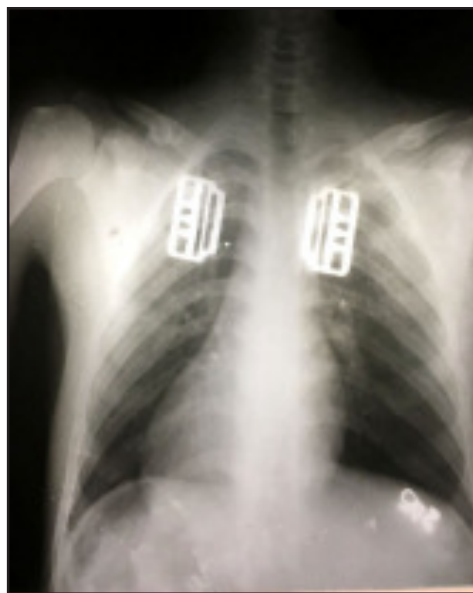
Showing chest xray with bilateral mid clavicular fracture treated by brace
